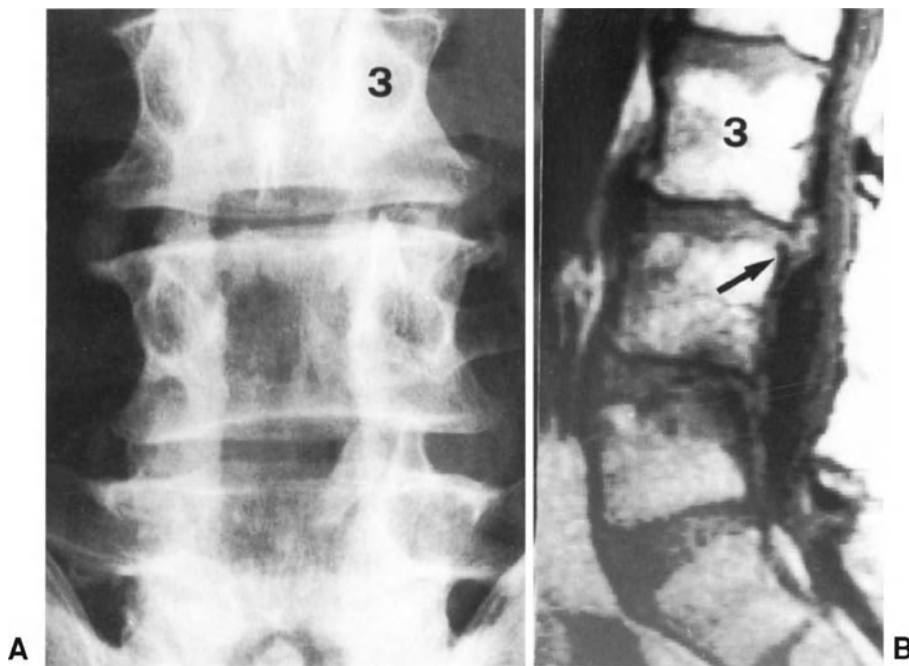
This patient (A) with spinal stenosis at L3-L5 and disc herniation at L3-L4 and L4-L5 levels had undergone L3-L5 central laminectomy and L4-L5 discectomy. MRI performed 3 months after surgery (B), due to persistence of radicular symptoms, showed compression of the neural structures by an L3-L4 herniated disc (arrow) not removed at initial surgery.
